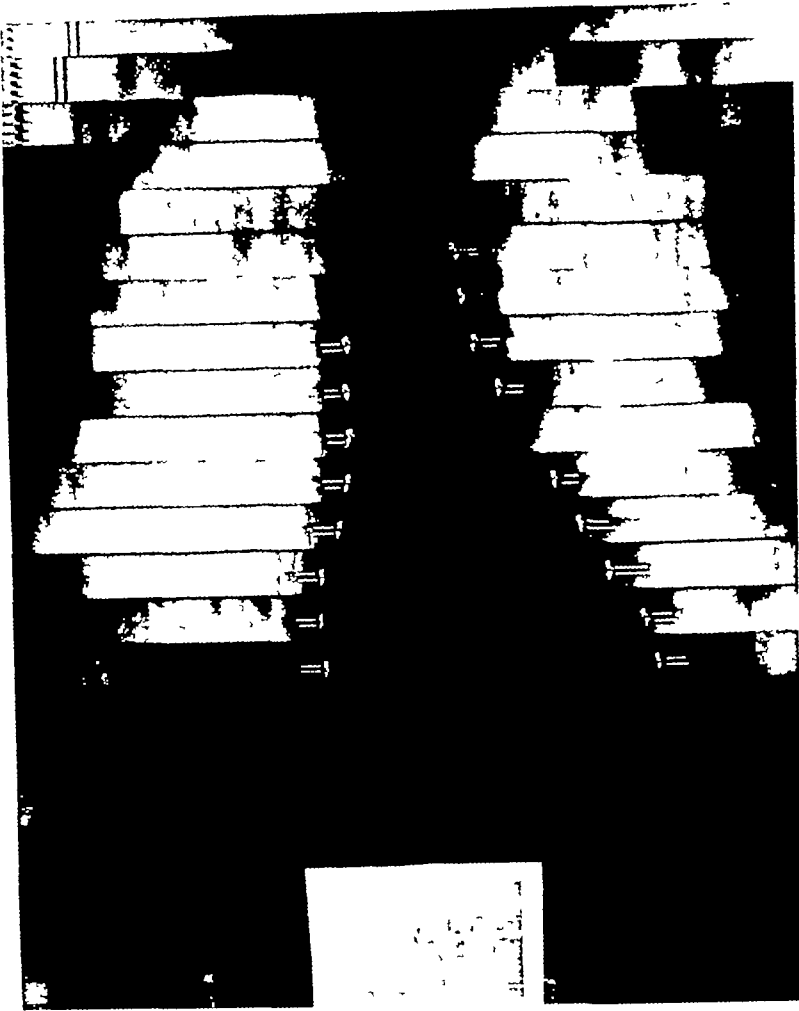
Roentgen kymogram showing the simultaneously made E K G record. Note the absence of any distortion of the E K G record. The exposure took place over the period indicated by the heavy line under the E K G waves. The relative positions of the peaks of the R and P waves are indicated on the kymographic waves. In the upper left hand corner are time marker divisions indicating fifths of a second.
